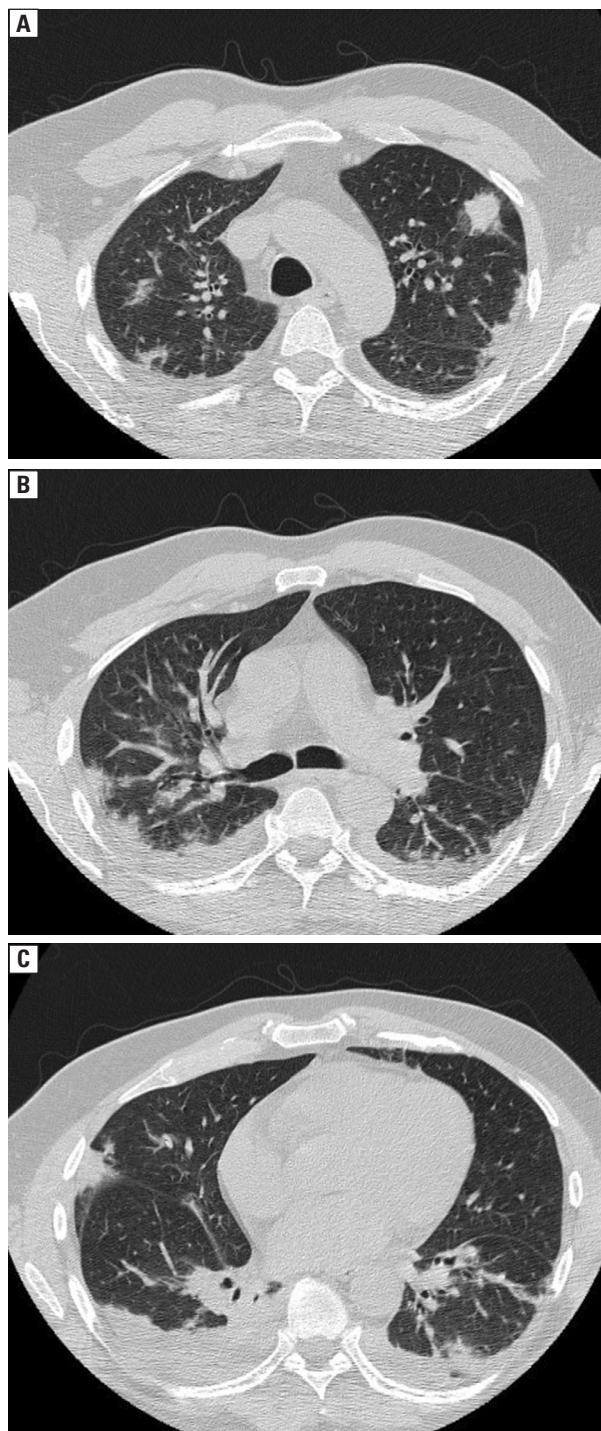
Chest computed tomography scan before his admission to the negative pressure room (day 4)
